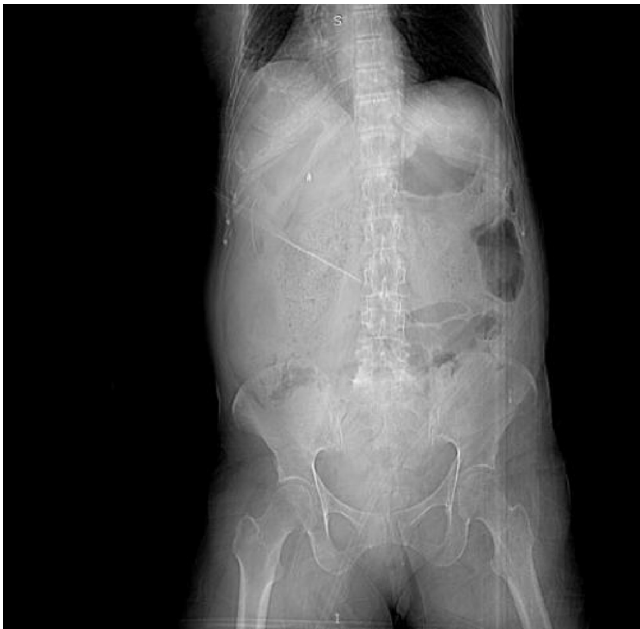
Preoperative CT Abdomen/Pelvis showing significant amount of fecal matter within the pelvis.
